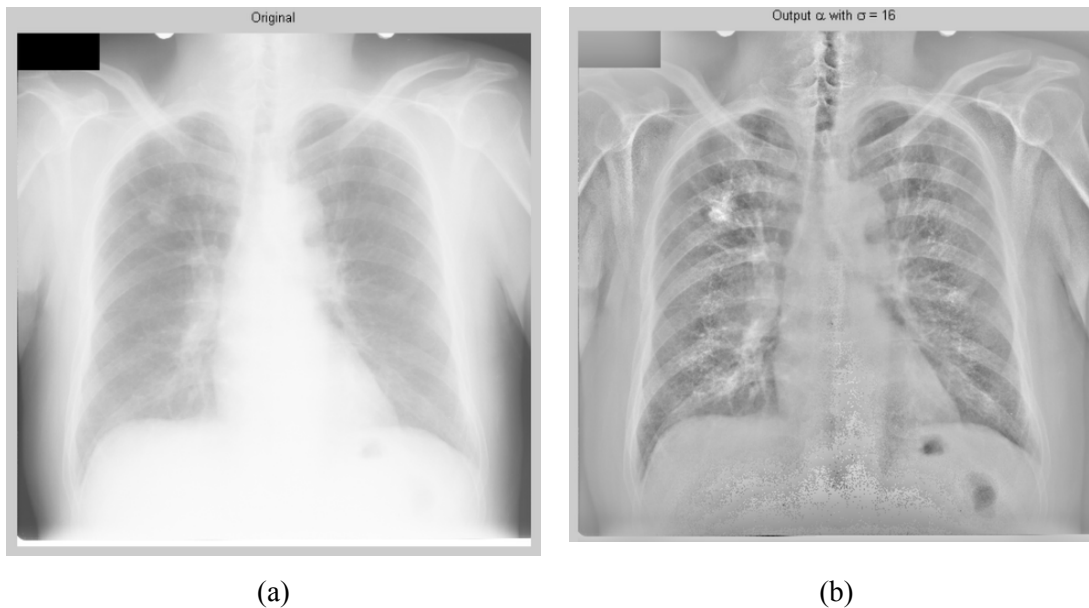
(a) Original chest radiograph; (b) The result of applying the local normalization filter ($\sigma = 16$).
